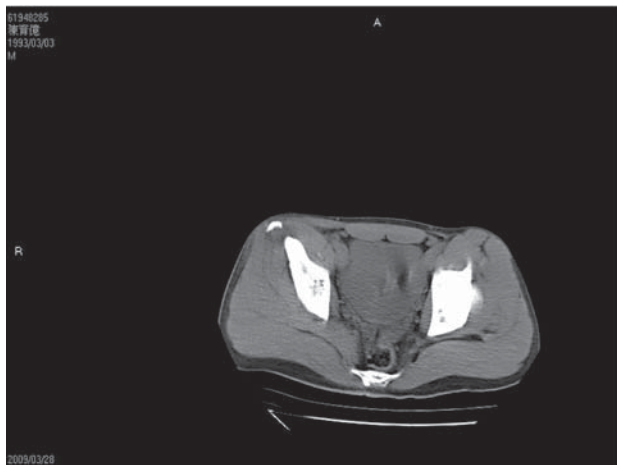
Computed tomography scan showed an avulsion fracture of the right ASIS with perifocal soft-tissue swelling.
